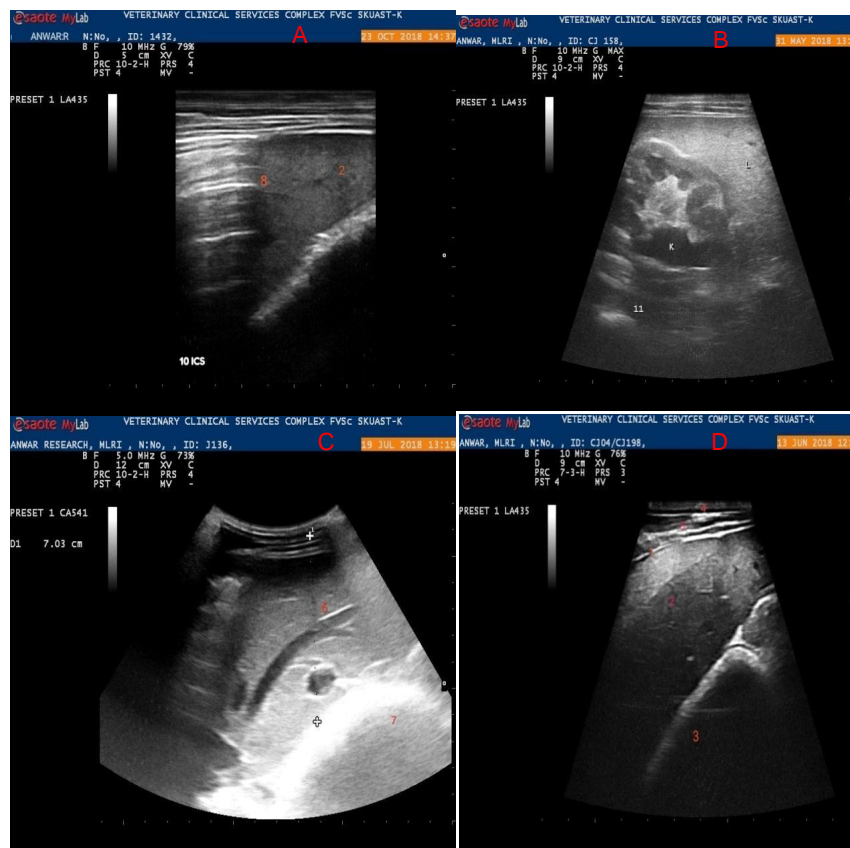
Real time ultrasonogram of liver 1. Capsule, 2. Parenchyma 3. Reticulum 4. Abdominal wall 5. Muscles and fascia 6. Ramification of portal vein 7. Omasum 8. Lung –liver interface at 10 ICS. 9. Kidney liver interface at 11 ICS
